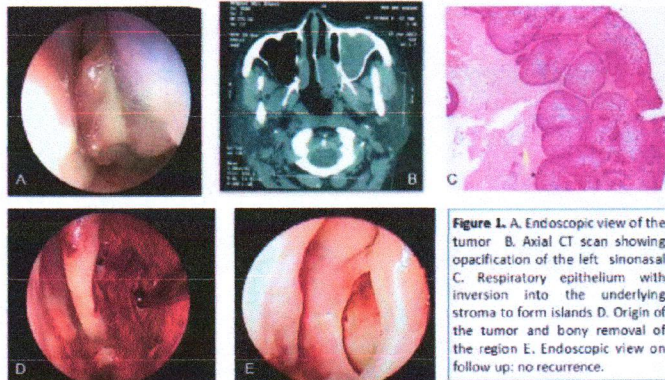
A. Endoscopic view of the tumor B. Axial CT scan showing opacification of the left sinonasal C. Respiratory epithelium with inversion into the underlying stroma to form islands D. Origin of the tumor and bony removal of the region E. Endoscopic view on follow up: no recurrence.
